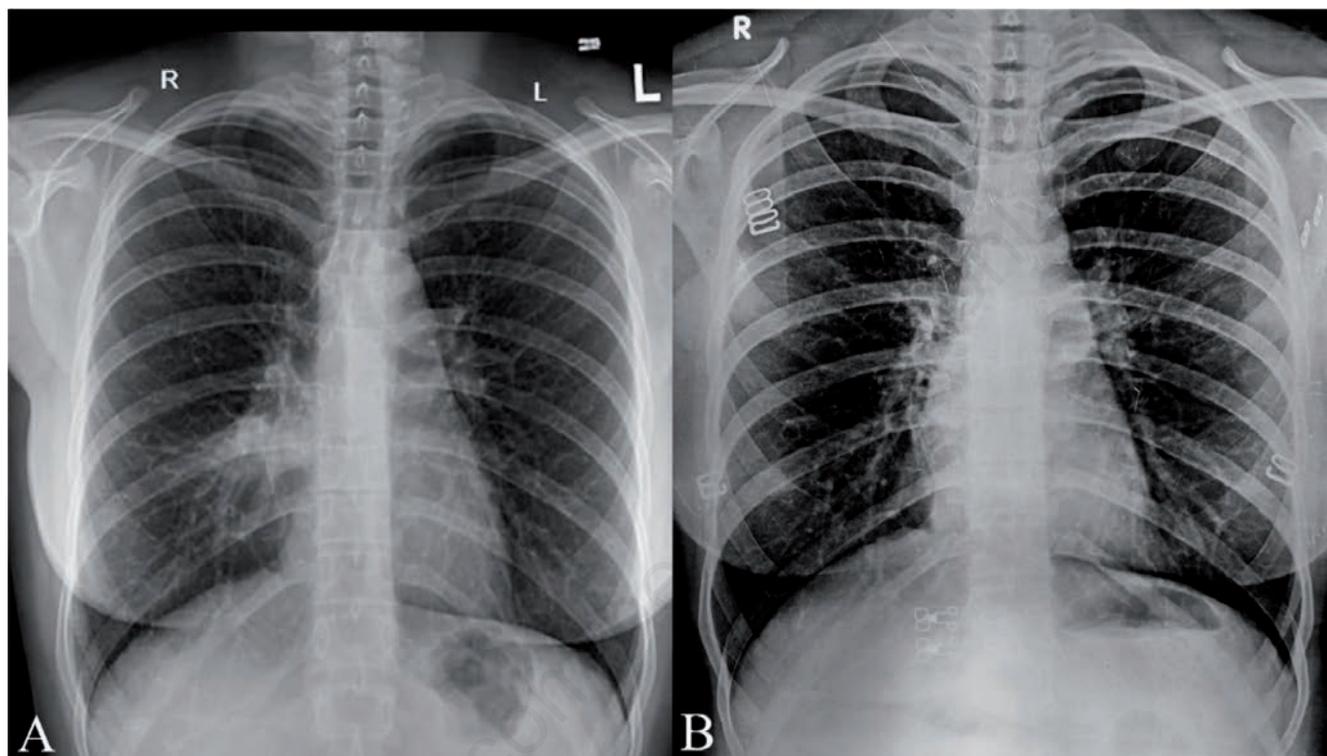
Patient's chest radiograph at the time of presentation (A), and after 6 weeks of treatment with 0.75 mg/kg prednisolone and itraconazole 200 mg BD (B).
